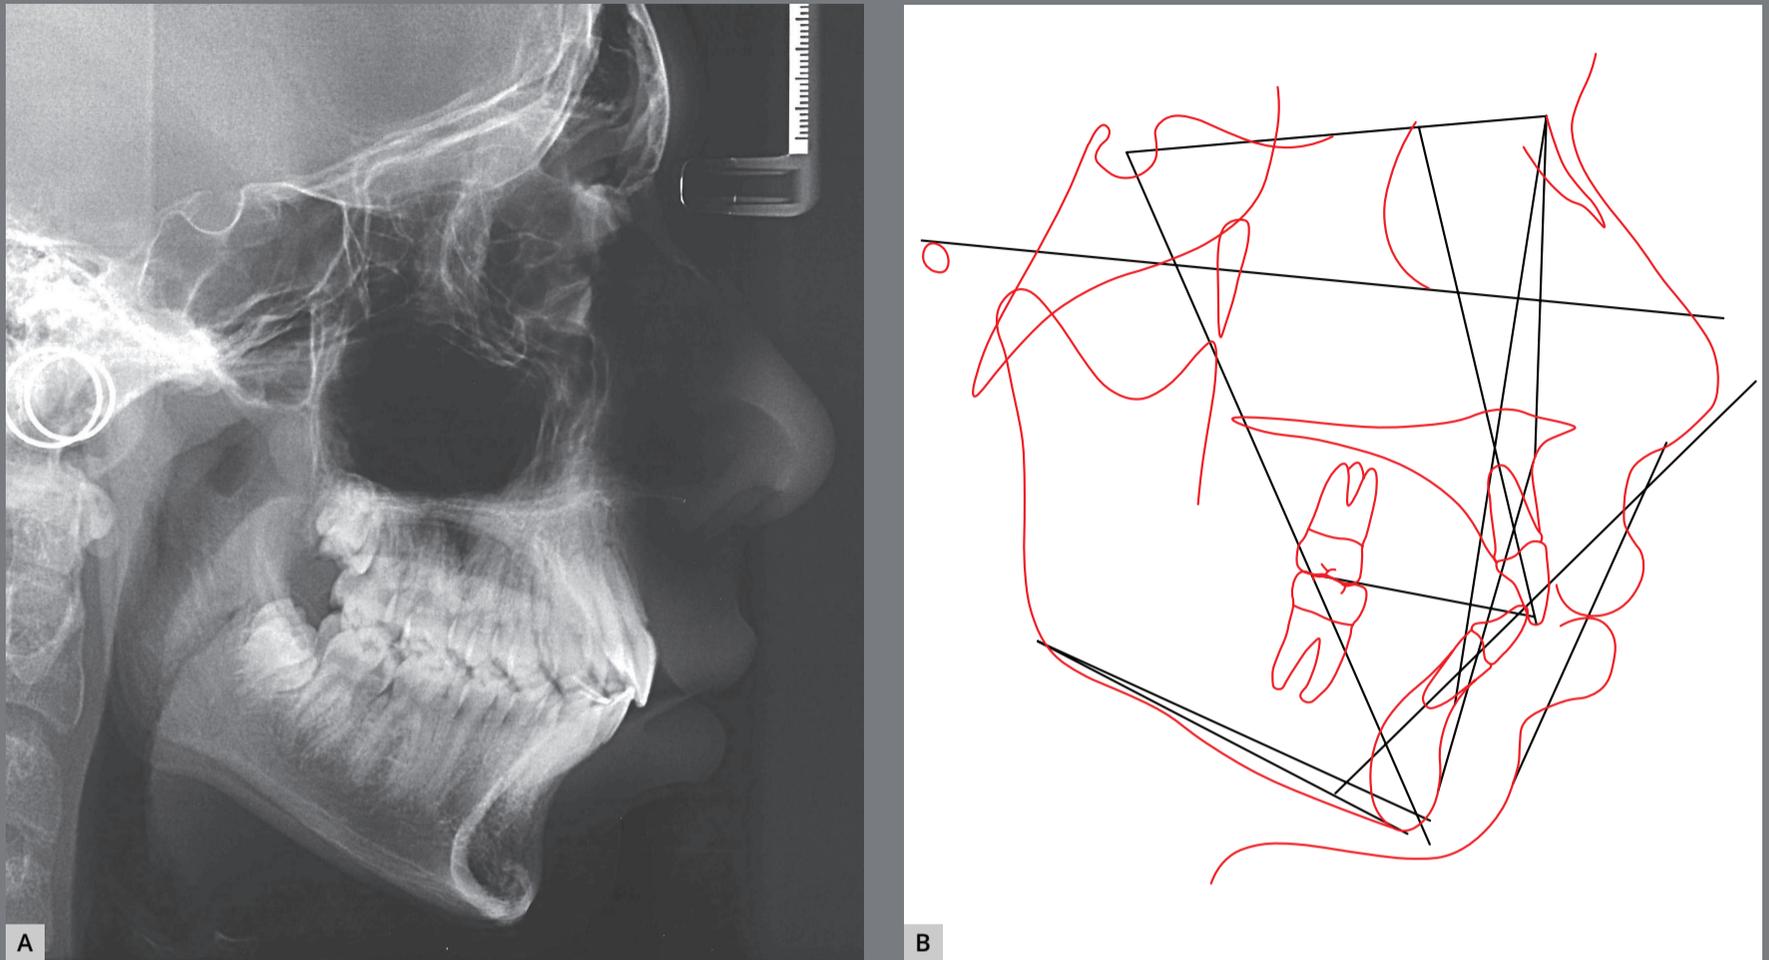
Final cephalometric radiograph of facial profile (A) and cephalometric tracing (B).
